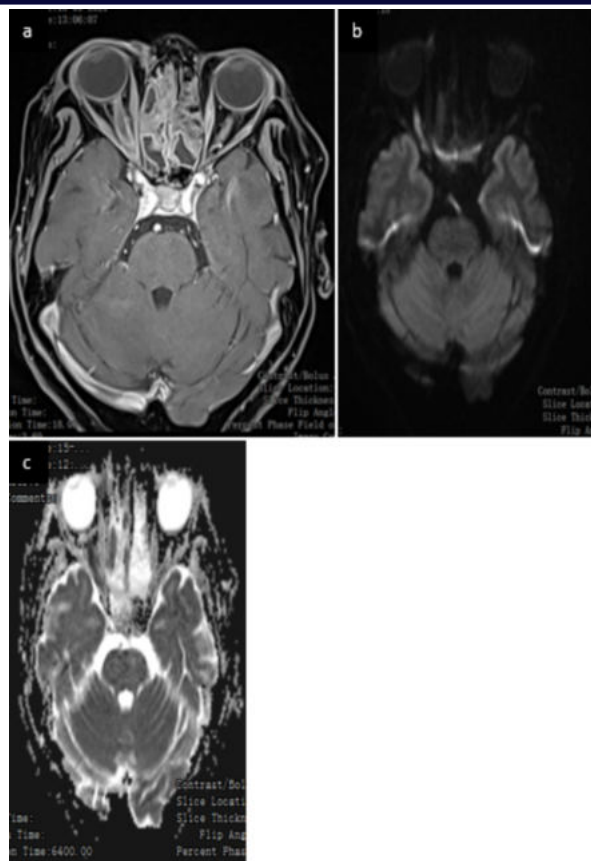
32 year old patient of ROCM with sudden loss of vision in Rt eye a) Postcontrast T1 Axial shows enhancement of bilateral nasal cavity and ethmoid sinuses with thickening and peripheral enhancement of right optic nerve B) & c) DWI & ADC show diffusion restriction suggestive of Optic Nerve Infarction.
